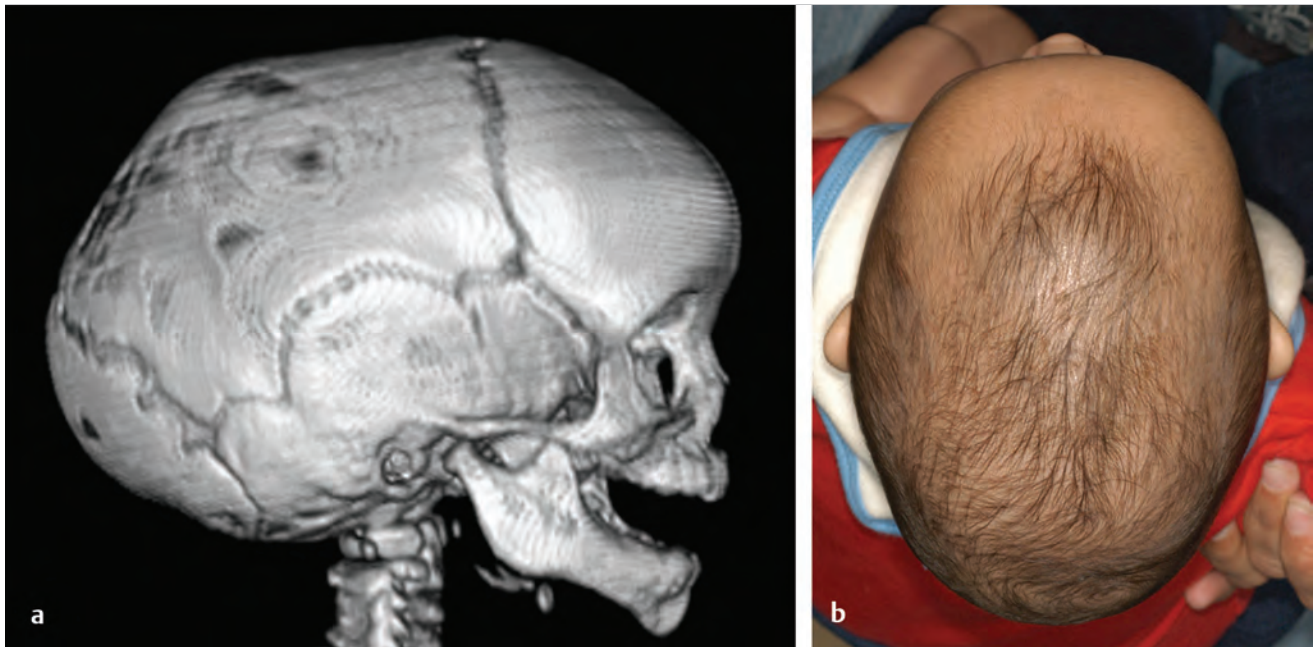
Sagittal synostosis. (a) Lateral CT image showing cranial elongation. (b) Apical photograph of an affected patient.
